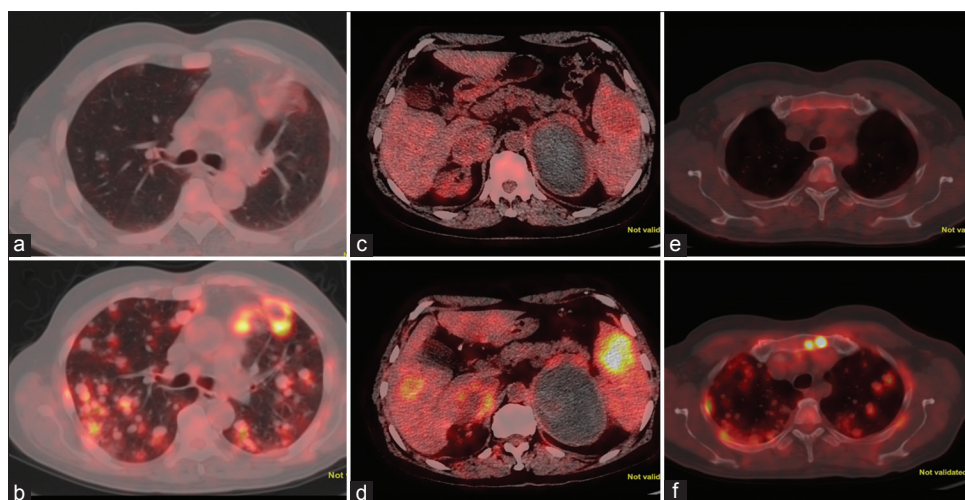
Fused axial pre-therapy positron-emission tomography-computed tomography image showing nodules in the right lung (a) which increased in size and fluorodeoxyglucose uptake in post-therapy scan. (b) Fused axial pre-therapy image (c) showing mildly fluorodeoxyglucose avid hypodense lesion in the spleen which increases in size and fluorodeoxyglucose avidity in post-therapy scan. (d) However, no significant change in Fluorodeoxyglucose avid liver lesion in segment V is seen. No significant fluorodeoxyglucose uptake is seen in the sternum (e) whereas post-therapy scan (f) shows increased fluorodeoxyglucose uptake in the sternum with no cortical changes suggestive of marrow metastases
